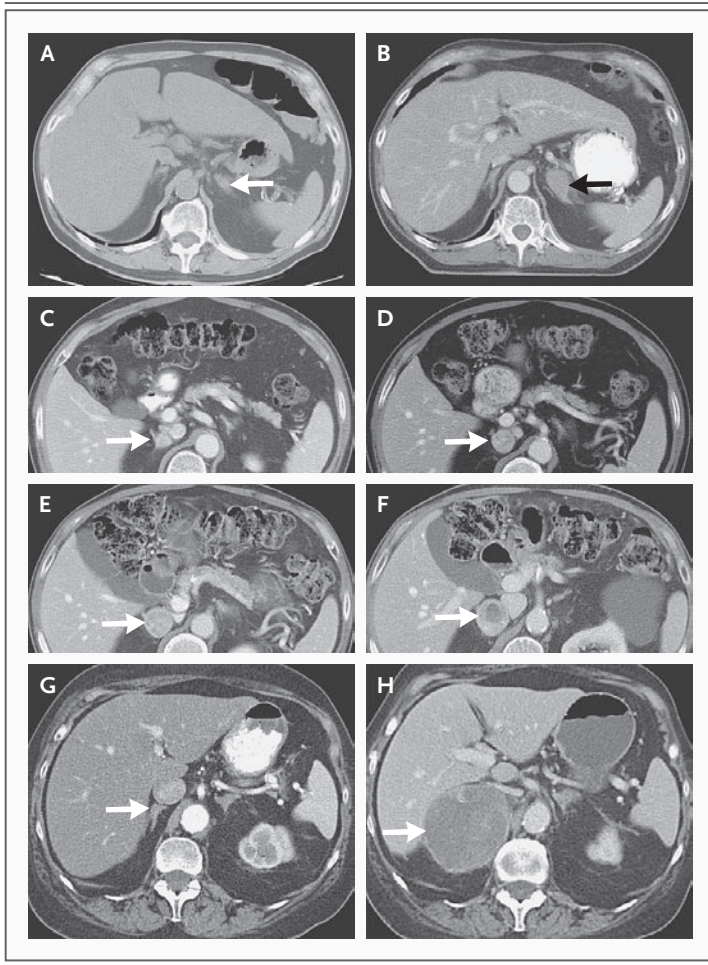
Serial CT Scans Showing Metastatic Disease to the Adrenal Gland (Panels A and B), a Benign Pheochromocytoma (Panels C through F), and Adrenocortical Carcinoma (Panels G and H).
